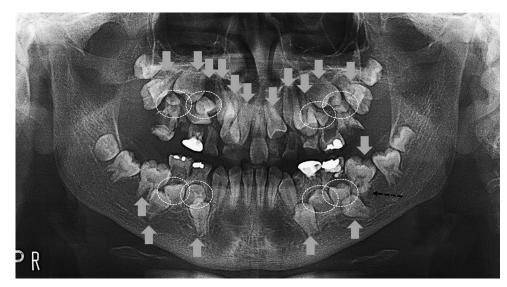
Orthopantomogram of case 6 (14 years 9 months). There are eight supernumerary teeth germs in the maxillary and mandibular premolar regions (dotted circle), which developed at the occlusal position to the permanent premolars. One supernumerary tooth germ developed at the apical and distal position to the lower left first molar (black arrow). A total of 17 impaction or delayed eruption of permanent teeth were observed (gray arrow).
